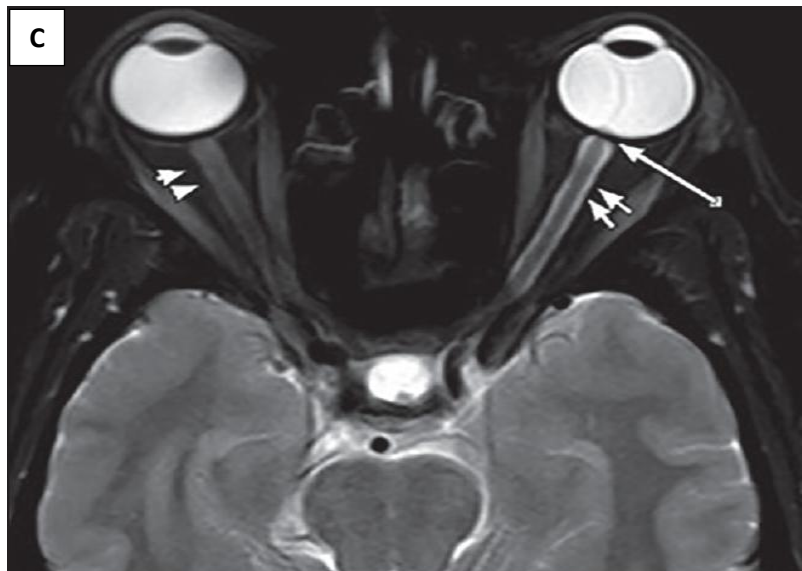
showing T2 axial magnetic resonance imaging scan of orbit shows distension of the optic nerve sheath in intraorbital segment of optic nerve bilaterally
